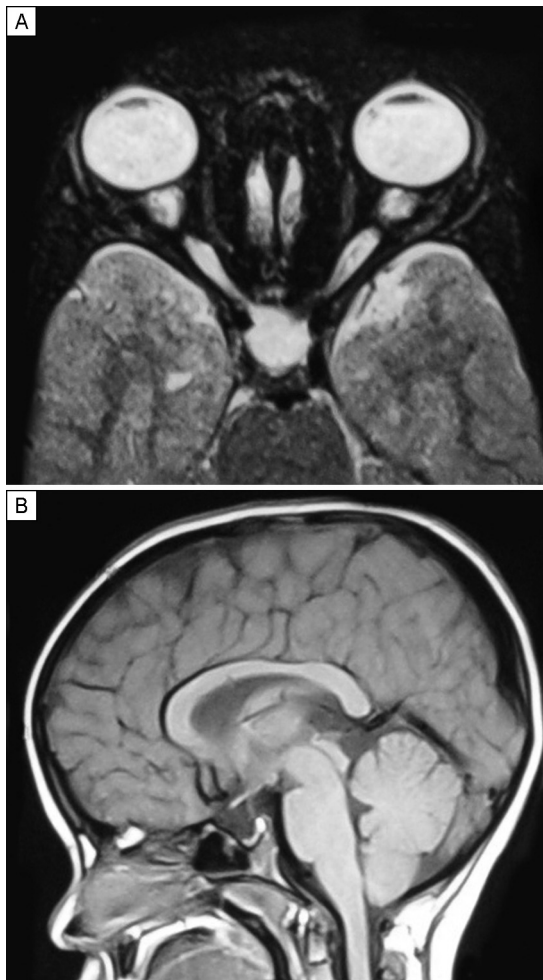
Magnetic resonance imaging showing the vertical buckling of the optic nerve (A), partially empty sella (B), suggestive of raised intracranial pressure.
